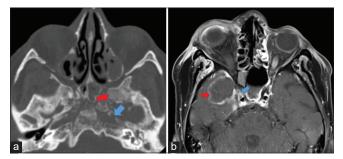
(a) CT axial image showing extensive erosion of the greater wing of the sphenoid more on the left side (red arrow) as well as erosion along the left carotid canal (blue arrow). (b) Post-contrast T1 axial image shows disease within the right cavernous sinus (blue arrow) with adjacent intracerebral rim enhancing abscess (red arrow)
